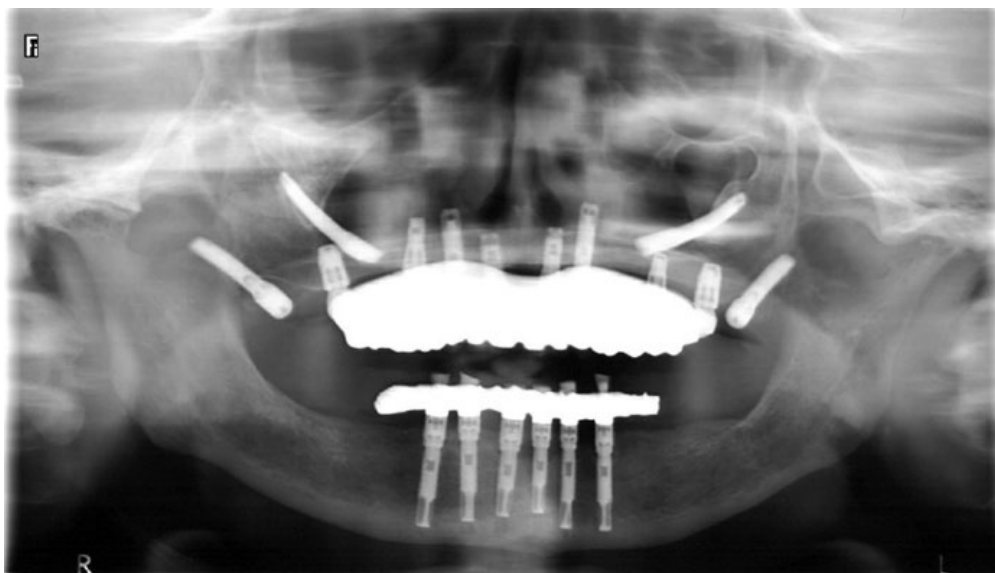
(D) After treatment: panoramic radiograph demonstrates new prosthesis in place with four new implants for fixed retention and unloading and submersion of the zygomatic implants.
